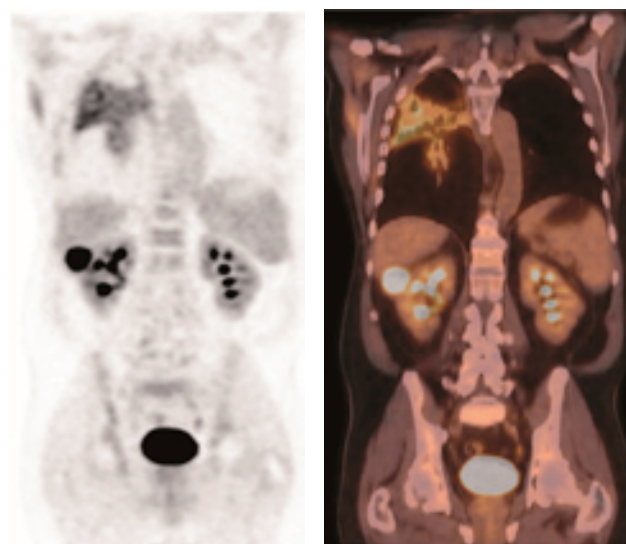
A 70 year old man with lung cancer metastatic to right kidney. Coronal ^{18}F -FDG-PET and fused PET/CT images demonstrate exophytic 3.0cm ^{18}F -FDG avid mass in interpolar right kidney with SUVmax 20.5, SUVmean 10.7, partial volume corrected SUVmean of 13.9, LBRliver 5.4, and LBRkidney 6.3. Mildly ^{18}F -FDG avid radiation change is also seen in right upper lobe of lung.
